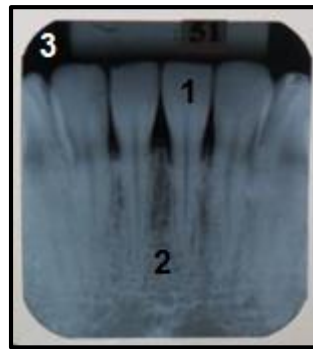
Periapicals radiographs identified by numbers and letters.
